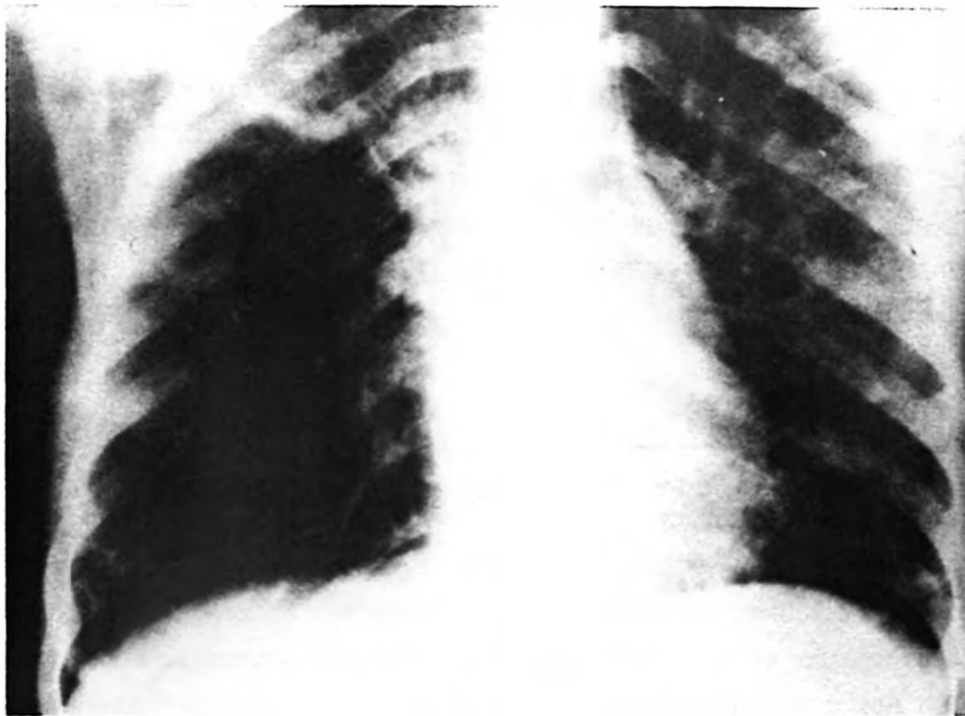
Posteroanterior radiograph showing typical reticular, cystic and nodular abnormalities of pulmonary LCH, termed honeycomb pattern.
